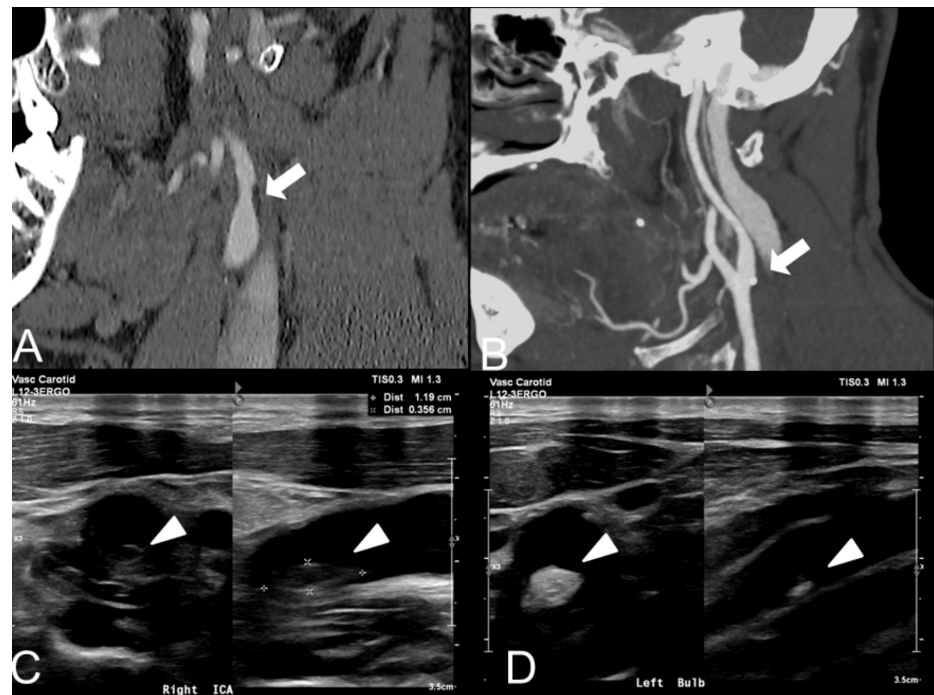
CTA and carotid duplex ultrasonography demonstrating bilateral nonocclusive atherosclerotic disease of the carotid arteries
